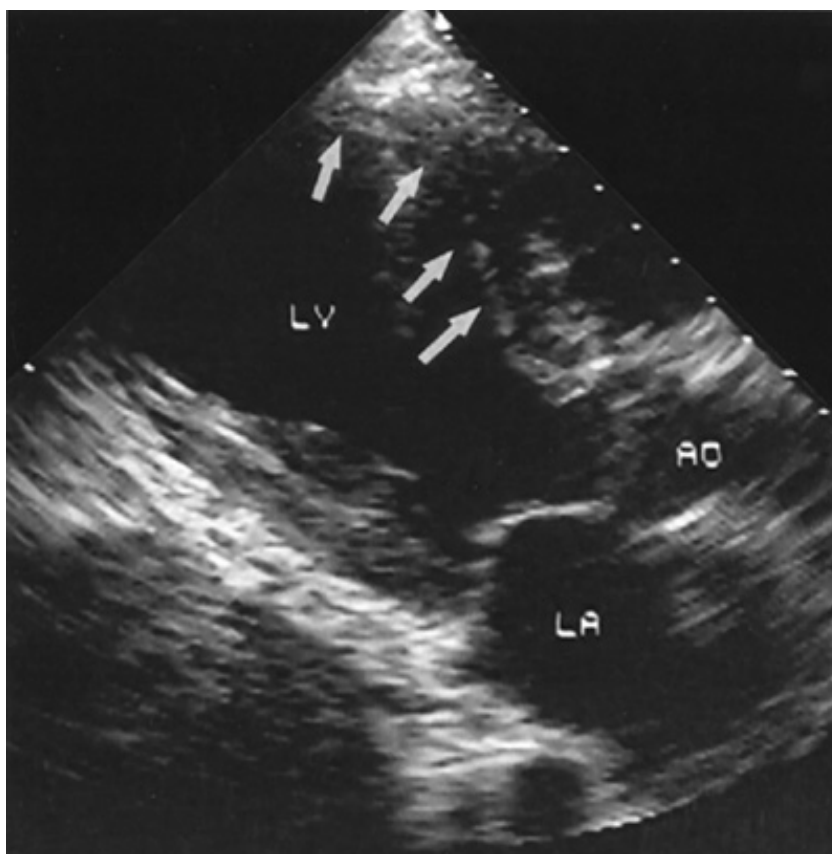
Parasternal long-axis view of a large anteroseptal myocardial infarction, with thinning and dyskinesia of the anteroseptal wall (*arrows*). LV = left ventricle; LA = left atrium; AO = aorta.
